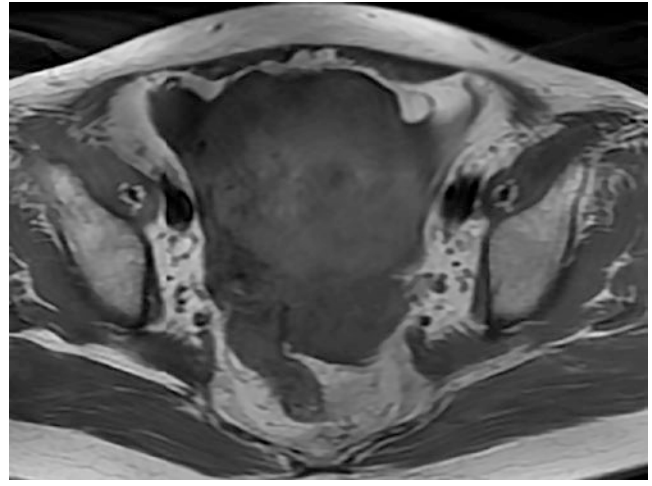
Axial T1-weighted image showed an oval lesion of slightly high signal intensity
